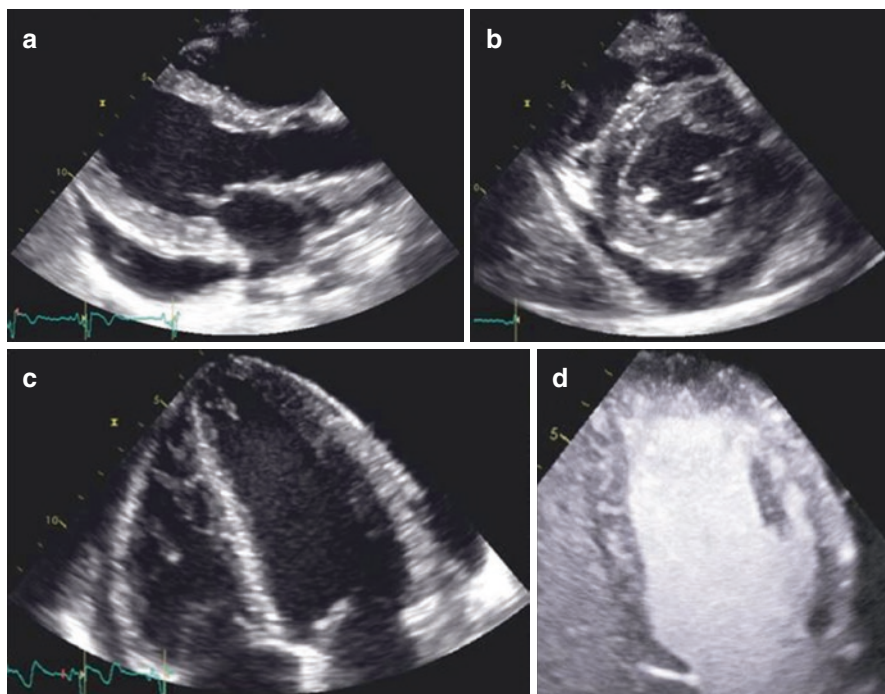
Echo findings in a patient with fulminant lymphocytic myocarditis. (a) Parasternal long axis (PLAX), the inferolateral wall is bright and thickened due to edema. There is a moderate pericardial effusion. (b) Short axis (SAX) shows thickened inferior and inferolateral walls and mild–moderate pericardial effusion. (c) Trabeculated apex, suspicious for an apical thrombus is shown. (d) After contrast injection (Sonovue Bracco) no thrombus is confirmed in the left ventricular apex
